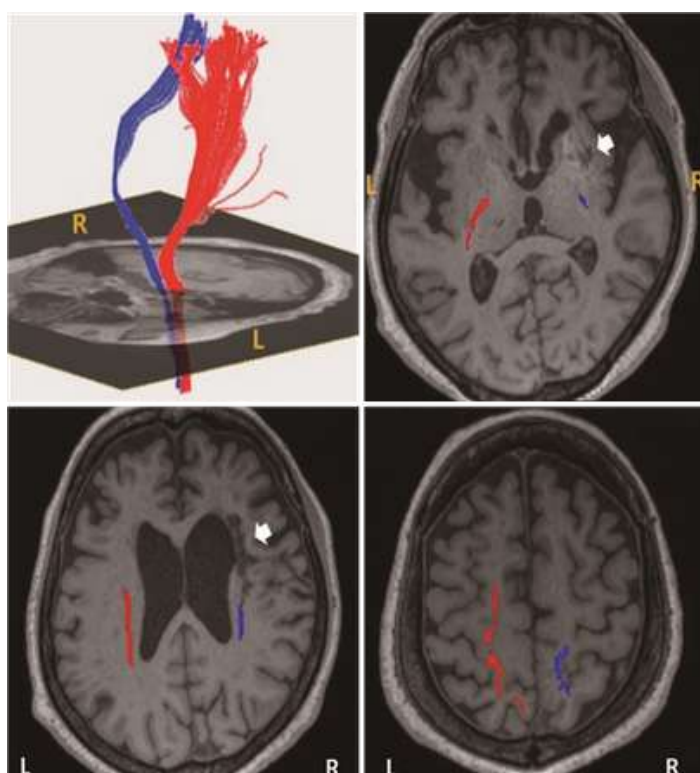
Three-dimensional diffusion tensor tractography (DTT) showing the corticospinal tracts reconstructed from diffusion tensor imaging (DTI). The tractography images are co-registered with T1-weighted MRI to demonstrate the anatomical relationship between white matter pathways and an intracranial lesion (white arrow).
